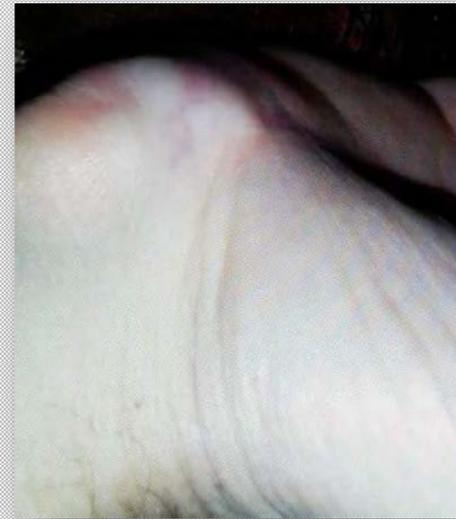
(Left) Appearance on clinical presentation. (Upper) MRI findings. (Lower) Results at 18 months without recurrence.
